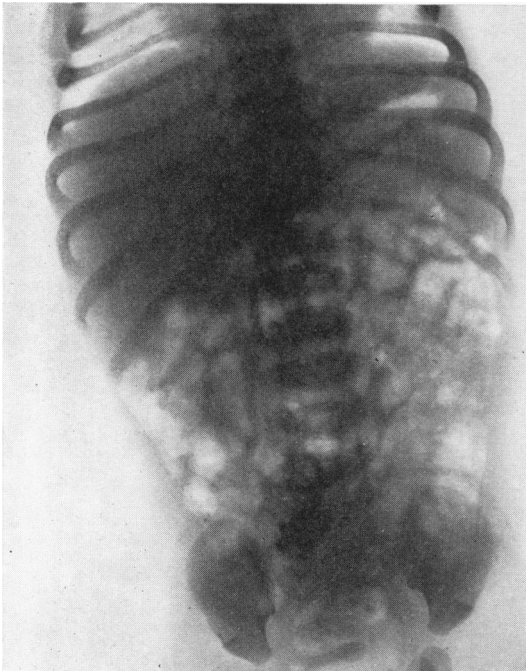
Radiograph of Case 5 after injection of iodized oil. Right periarterial abscess.
